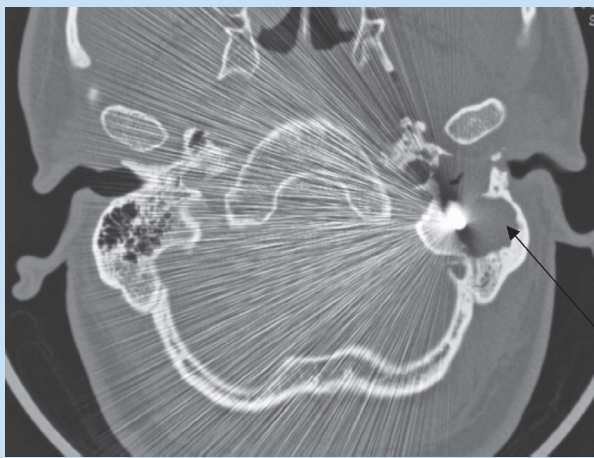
Axial CT displaying a bullet lodged in the mastoid secondary to the old trauma. Note the cholesteatoma extending into the mastoid (arrow).
